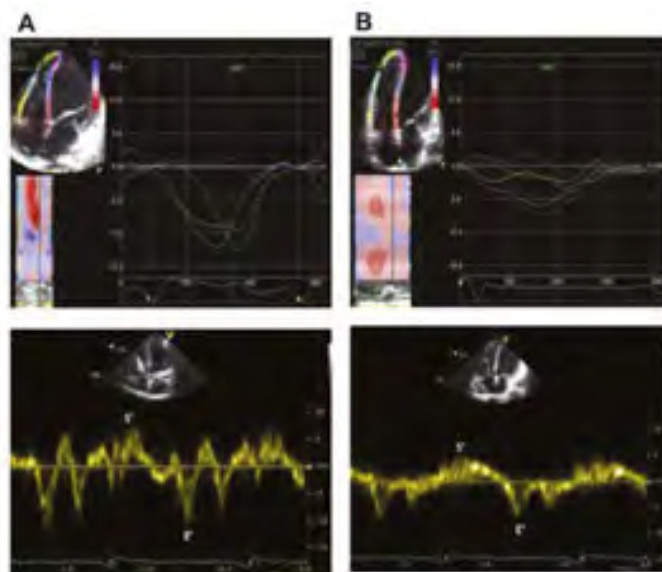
Representative global RV longitudinal strain and TDI obtained before surgery from a patient without RVF after LVAD and from a patient with RVF after LVAD (quoted from Ref. [18]). (A) The right ventricular (RV) global longitudinal strain; tissue Doppler image (TDI)-derived S' and E' for patient A was -14.3% , 7.8 cm/s and -10.8 cm/s, respectively. (B) These parameters were -6.2% , 4.6 cm/s and -5.3 cm/s, respectively. LVAD, left ventricular assist device; RVF, right ventricular failure.
